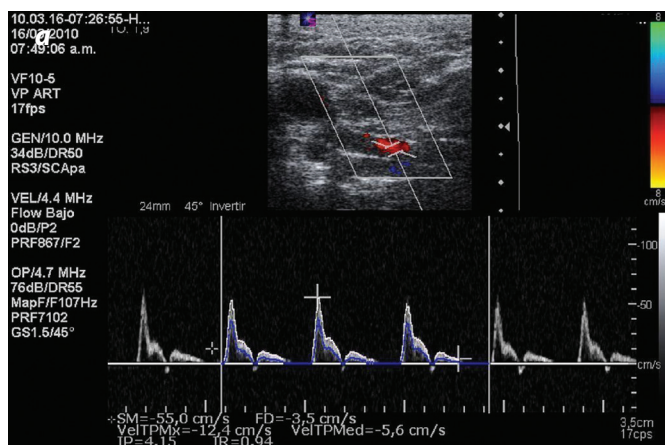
Triple mode Color Doppler ultrasound showing the subscapular artery in a male patient (a) and in a female (b)
